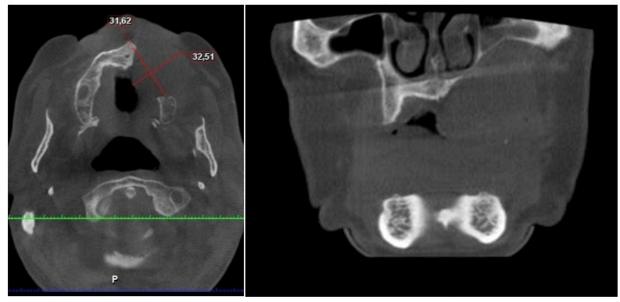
CBCT image showing well-defined, lytic expansile radiolucency in the left maxillary posterior region.
